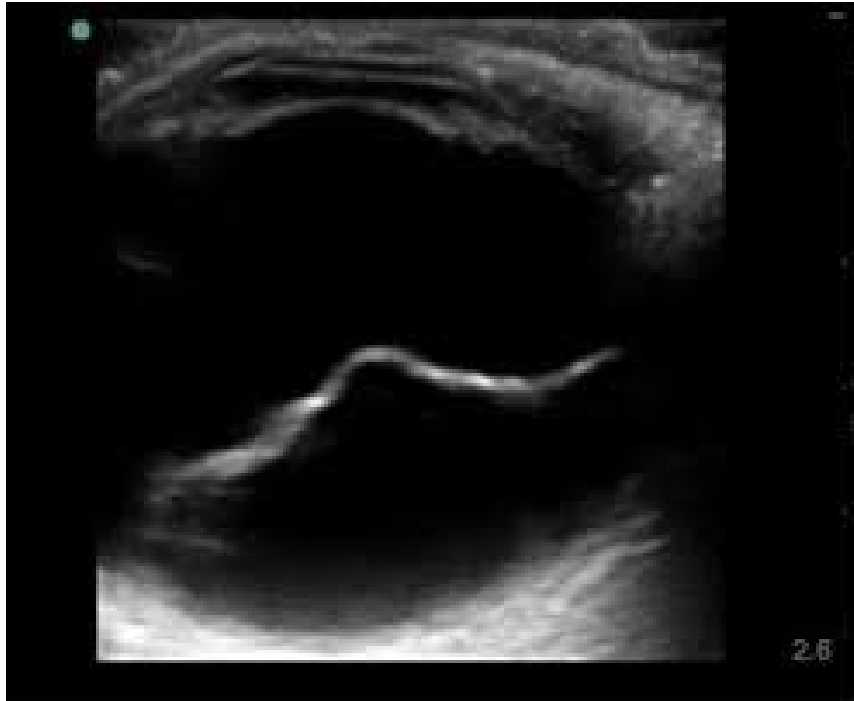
Ocular ultrasonography for retinal detachment [22].
